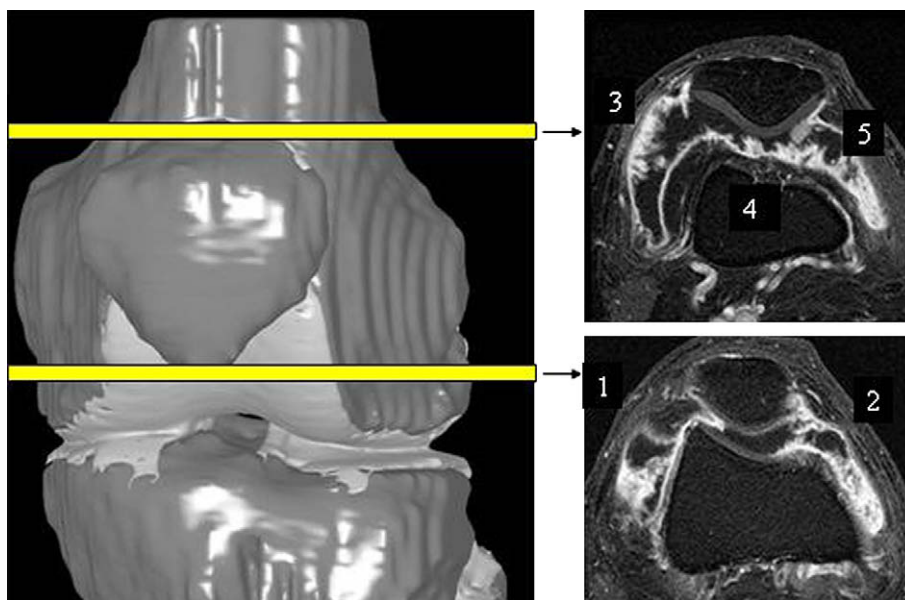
The two slices chosen for the MRI synovitis score corresponds to the first and the last axial post-injection T1-weighted slices in which the patella was still visible. SM inflammation was graded according to thickening severity in five ROI (1–5). The MRI synovitis score varied between 0 and 15. 254 × 190 mm (72 × 72 DPI).
